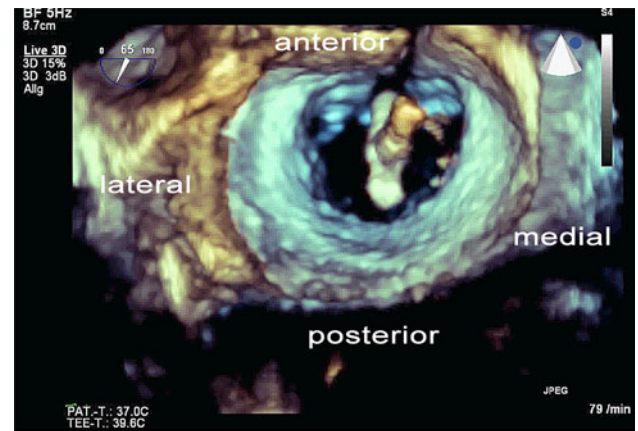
Left atrial echocardiographic 3D alignment of the MitraClip system, surgical orientation with alignment of the aorta at 11–12 o’clock
